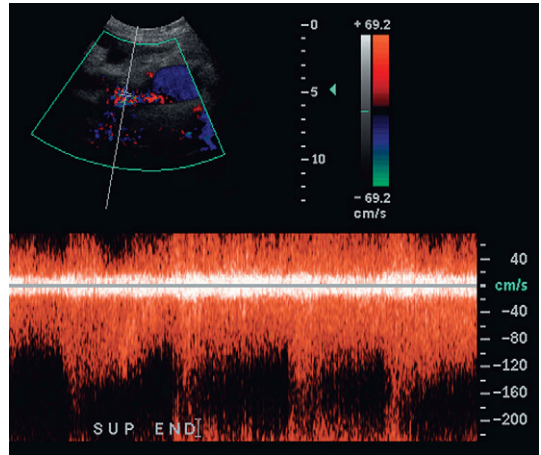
Colour and spectral Doppler image of a pancreas several days after a biopsy. High velocity, turbulent, low resistance arterial flow is present in an area of flash artifact. This was an arteriovenous fistula; a complication of the biopsy.
